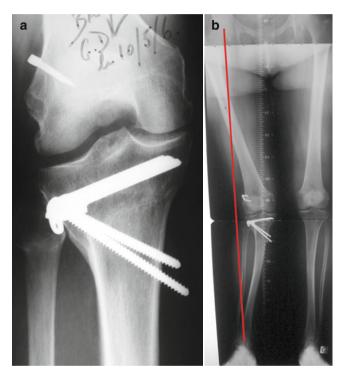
(a, b) X-rays showing significant overcorrection after closing wedge HTO
